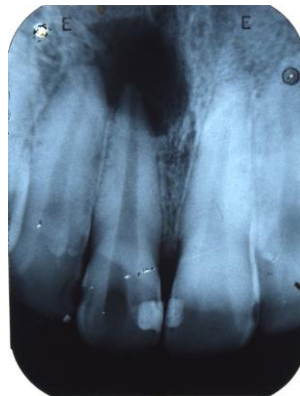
Preoperative Radiograph showing periapical radiolucency in relation to 11
